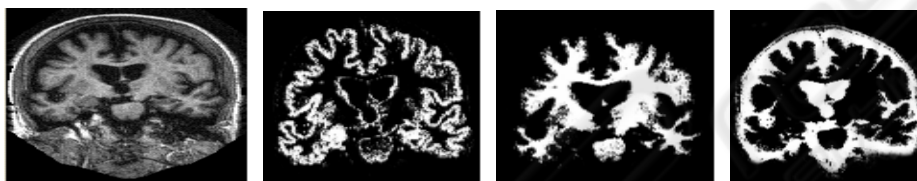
Brain structures segmented: (a) original MR image; (b) WM; (c) GM; and (d) CSF.
